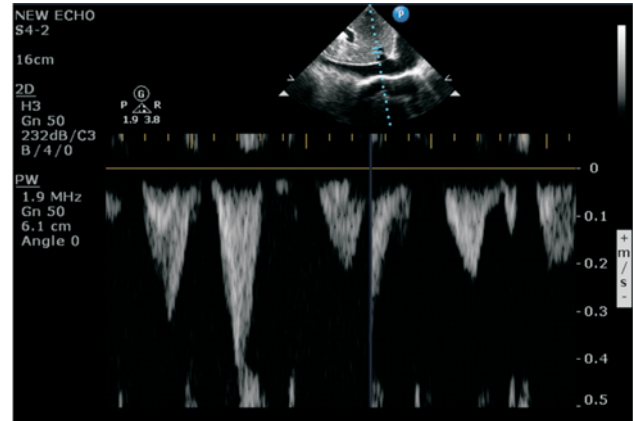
Pulsed wave Doppler at hepatic vein showing systolic velocity less than diastolic velocity.
